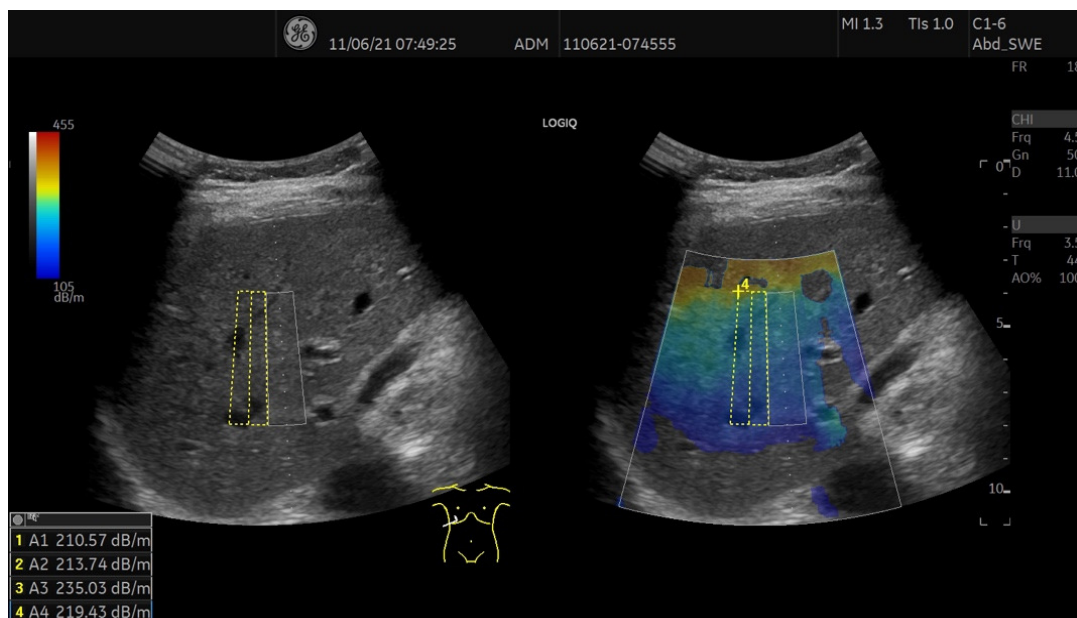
UGAP (Ultrasound-Guided Attenuation Parameter) developed by General Electric™
